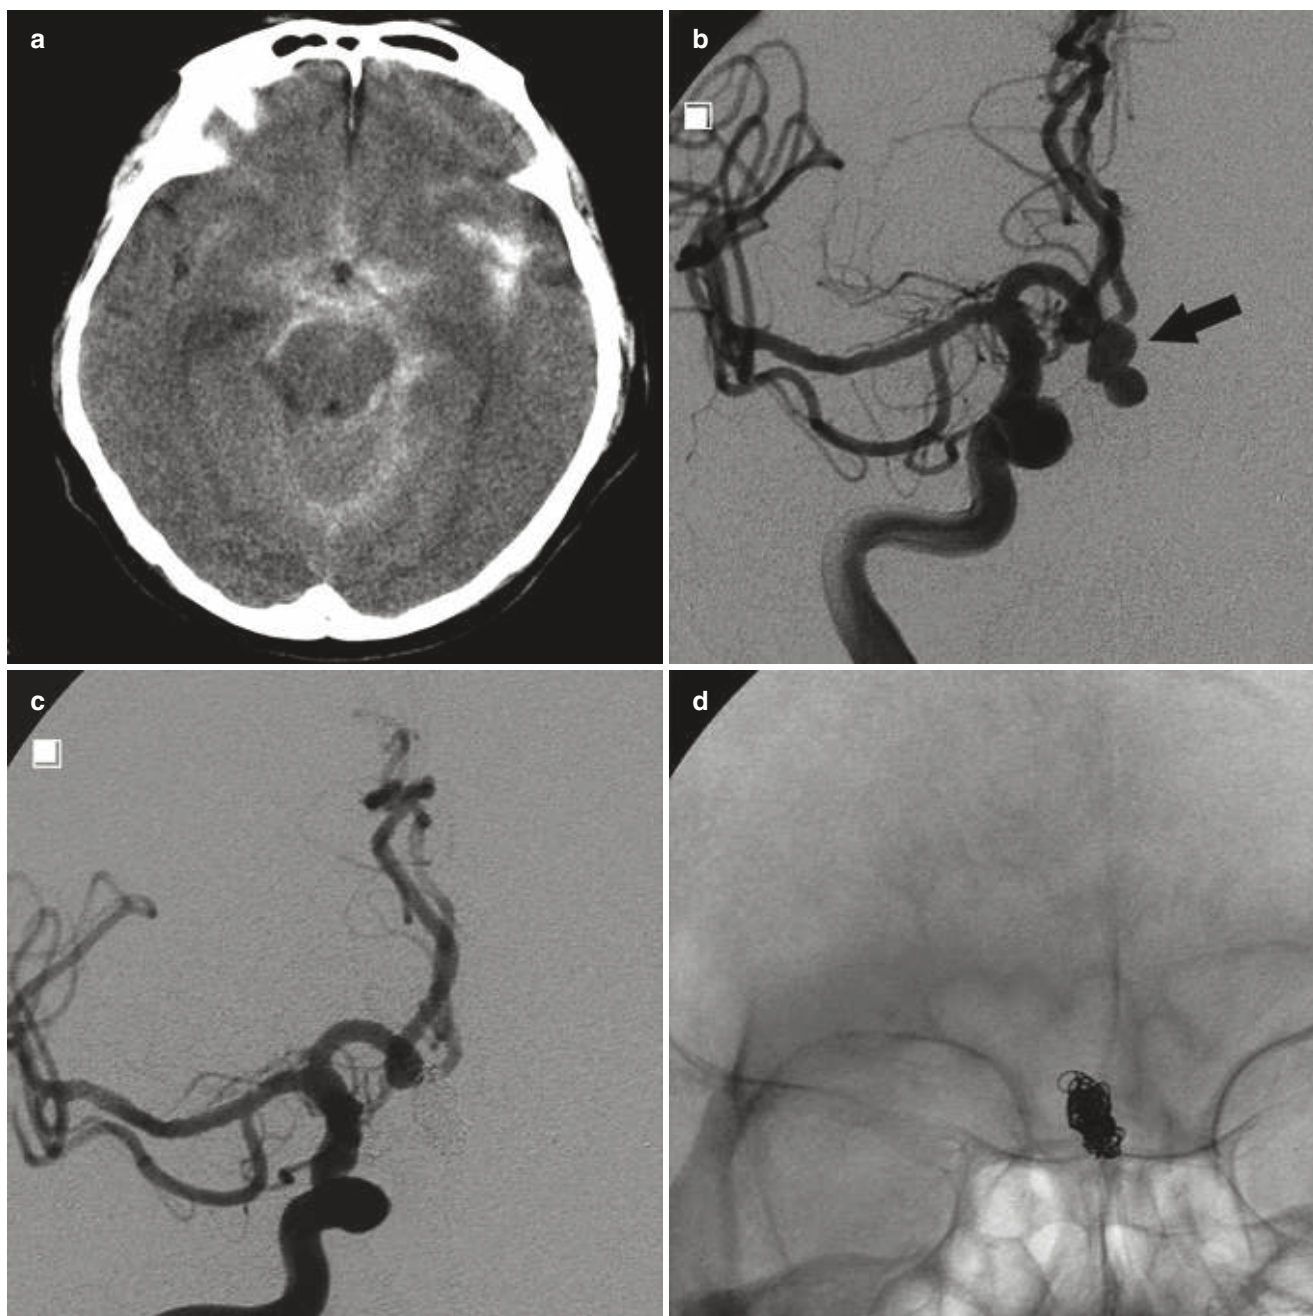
Subarachnoid haemorrhage (SAH). A 43-year-old man with acute headache, meningism, and progressing vigilance deficits. (a) Native CT, demonstrating the hyperdensity of the basal cistern, due to acute subarachnoid haemorrhage. (b) DSA of the right internal carotid
